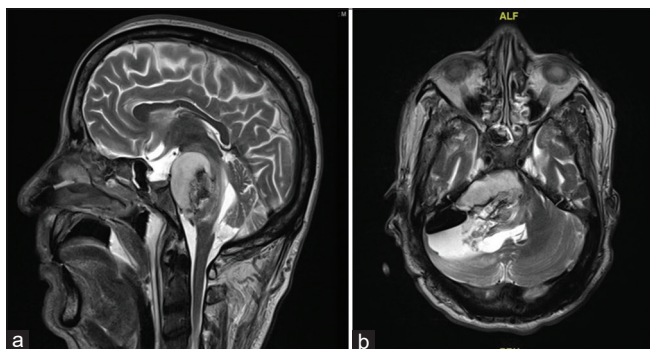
T2-weighted magnetic resonance imaging scans of the brain in the sagittal (a) and the axial (b) showing partially excised right cerebellopontine angle (CPA) tumour with right retromastoid suboccipital craniotomy defect with haemorrhagic residue and oedema in the right cerebellar hemisphere, right middle cerebellar peduncle, and the right hemipons, with additional haemorrhage and loculated blood mixed cerebrospinal fluid in the right CPA cistern
